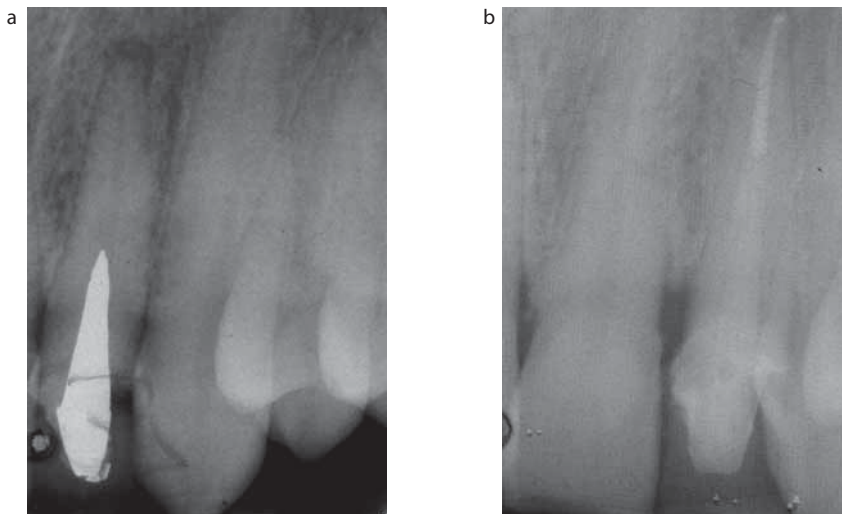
(a) Pre-operative radiograph. (b) Postoperative radiograph.
